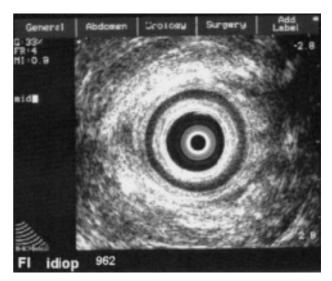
Idiopathic FI. No sphincter defect was detected in the endoanal ultrasound.
